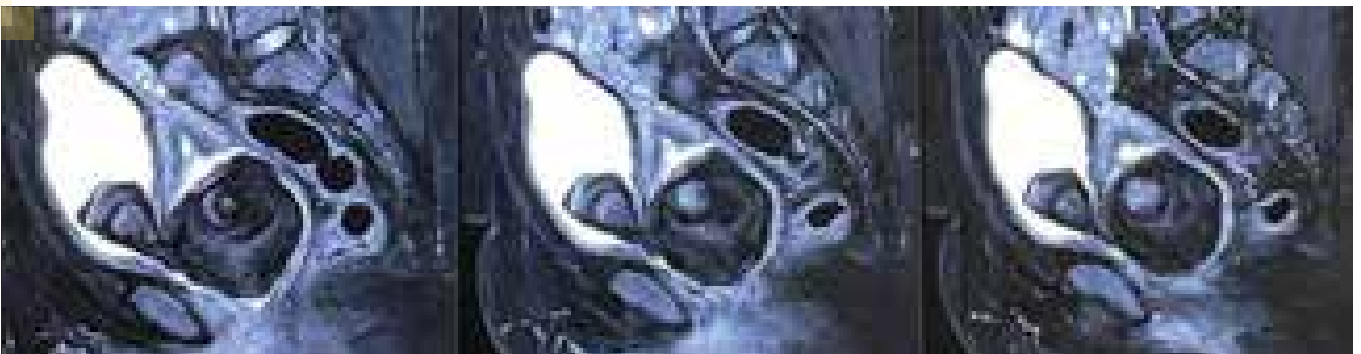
MRI pelvis showing large, calcified mass involving vagina and bladder
